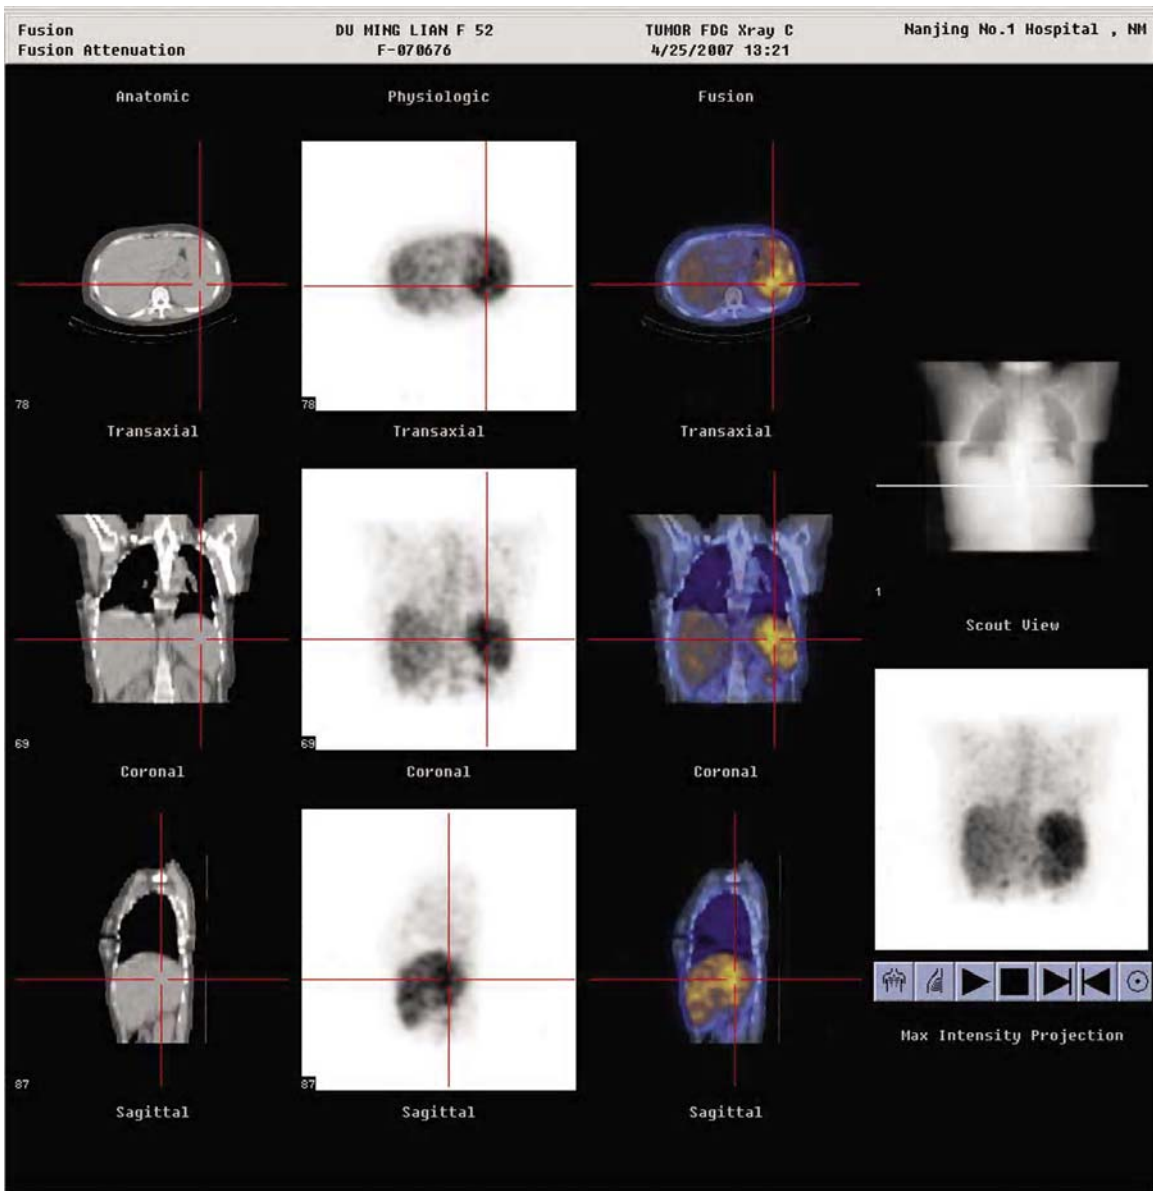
Tumor glucose metabolism image(PET-CT)
